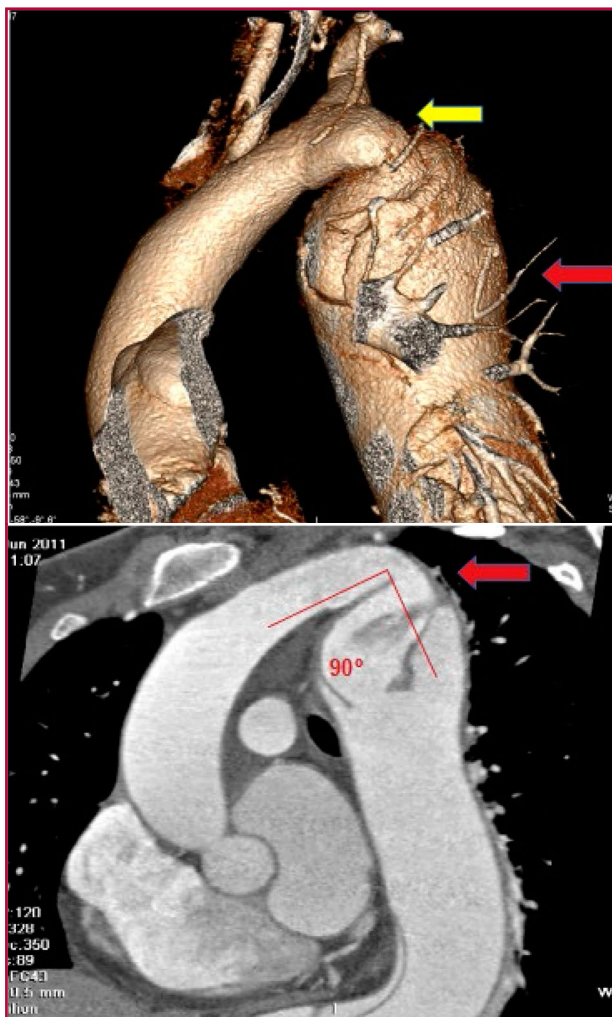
A. Preoperative 3D angio-CT reconstruction (Stage 1) depicting aortic recoarctation (yellow arrow) and descending dissecting aortic aneurysm (52 mm) (red arrow). B. Preoperative angio-CT scan (Stage 1) showing aortic recoarctation with 90° angulation in the distal aortic arch and post-coarctation hypoplasia (red arrow).
